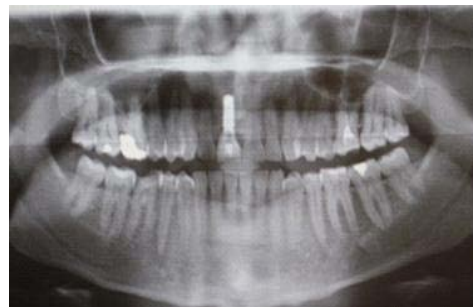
Panoramic radiograph immediately after screw-retained IPS e.max CAD crown positioning.
